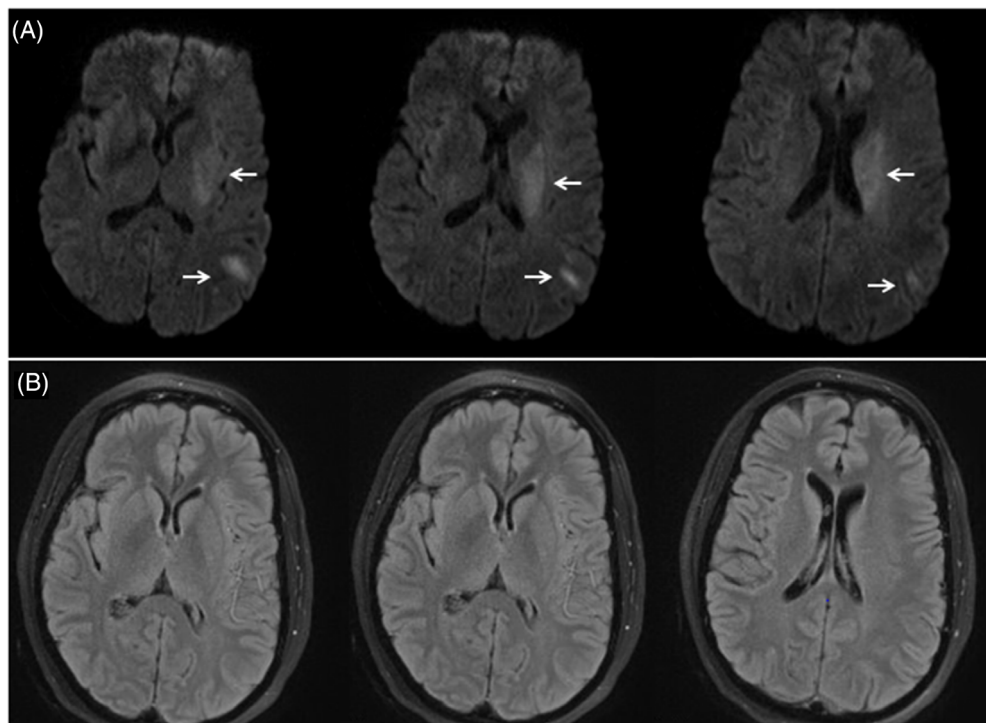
Diffusion/FLAIR mismatch. Panel A, Diffusion-Weighted Imaging (DWI) sequences with a restriction of diffusion (arrows show regions of early onset ischemia). Panel B, Fluid-Attenuated Inversion Recovery (FLAIR) sequences without any corresponding signal abnormalities.
